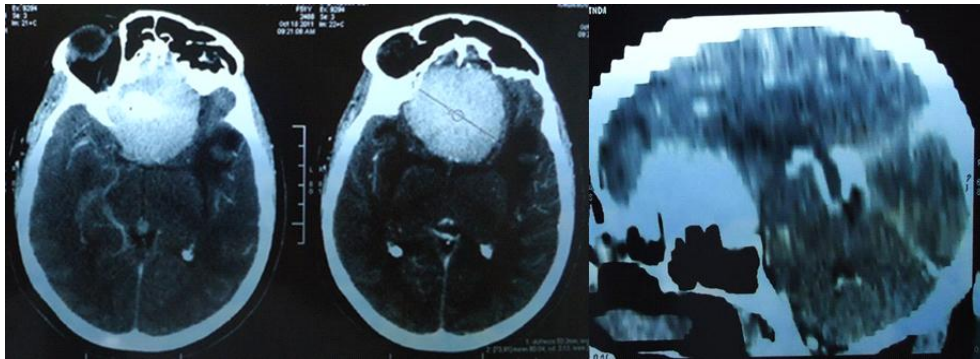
CT image of olfactory meningioma (axial and sagittal reconstruction)
